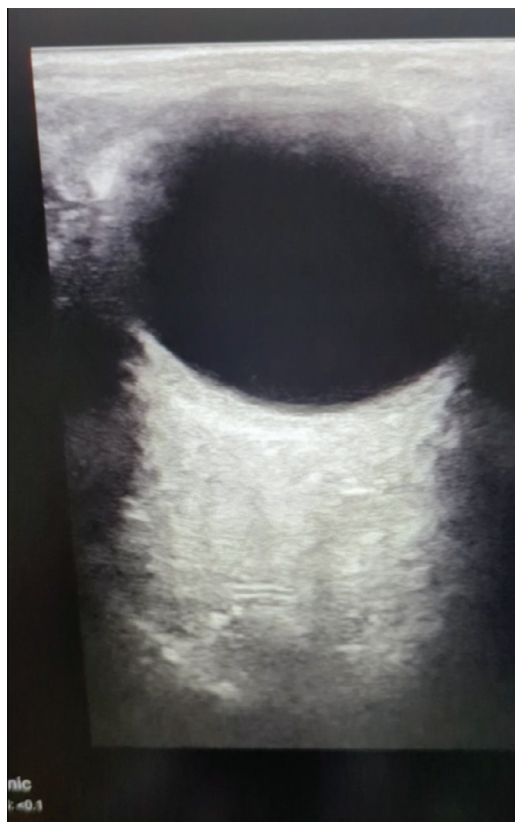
Ocular ultrasound of the left eye demonstrates a crescent sign (outlined in red) as well as elevation of the optic disc (outlined in blue).
